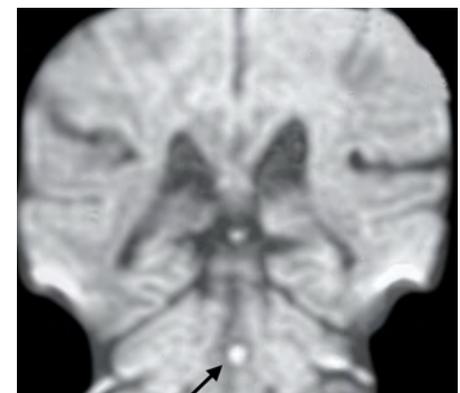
Magnetic resonance imaging of the brain, coronal diffusion-weighted imaging (DWI), showing acute left paramedian pontine infarct
